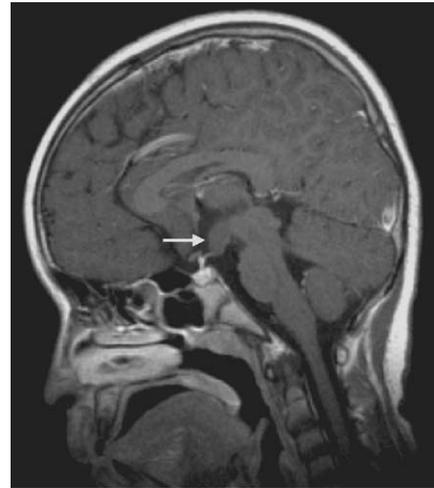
The sagittal T1-weighted image showing no enhancement of nodular mass posterior to the enhancing pituitary gland and stalk in the suprasellar region (arrow).
